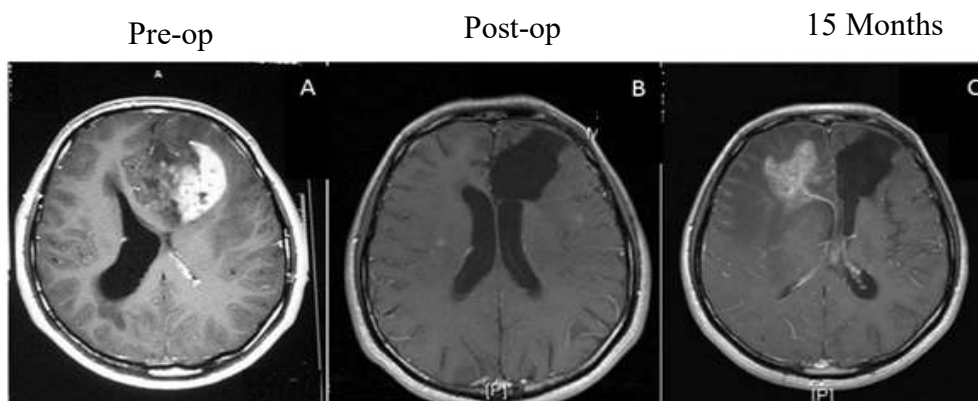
MRI image of a GBM patient with GBM tumor on right hemisphere, images taken pre-op, post-op and after 15 months (Seker-polat et al., 2022)
